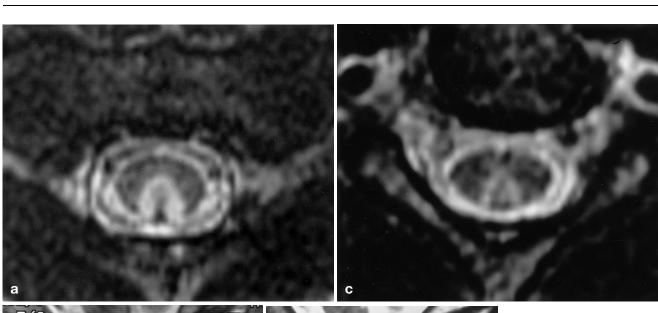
a,b Initial MRI of the cervical spine (a TR/TE/NEX 4500/95/2, b 4000/108/2) demonstrates a symmetrical area of T2 signal abnormality with cord expansion involving the dorsal columns of the cervical cord from C2 to C5. c,d Follow-up MRI of the cervical spine (c 4500/95/2, d 400/100/ 2) reveals a slight decrease in the extent of the abnormal T2 signal area in the posterior columns. There is no sign of contrast enhancement (not shown) and there is no longer any evidence of cord expansion
